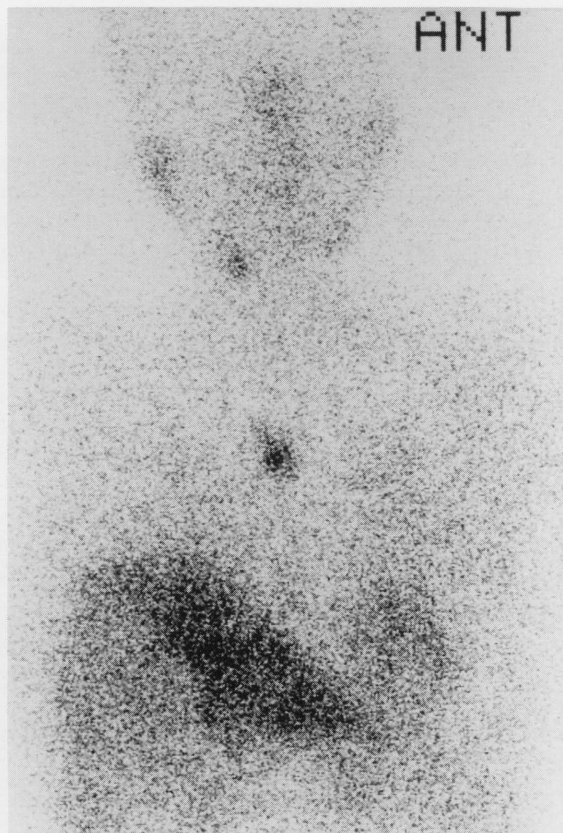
^{123}I -MIBG scintigram taken at 24 hours post injection showed an accumulation in the mediastinum and right salivary gland.
